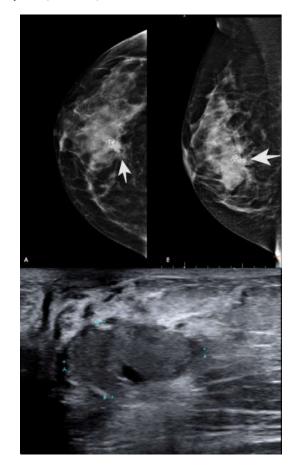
On top: Mammography in the Craniocaudal (A) and Mediolateral Oblique (B) views of the right breast showing coarse, heterogeneous and thin pleomorphic calcifications grouped in the central region (arrows), associated with architectural distortion. At the bottom: Ultrasonography of the right breast shows an oval, hypoechoic nodule, with non-circumscribed margins, parallel to the skin, associated with a certain architectural distortion later, in correspondence to mammography
